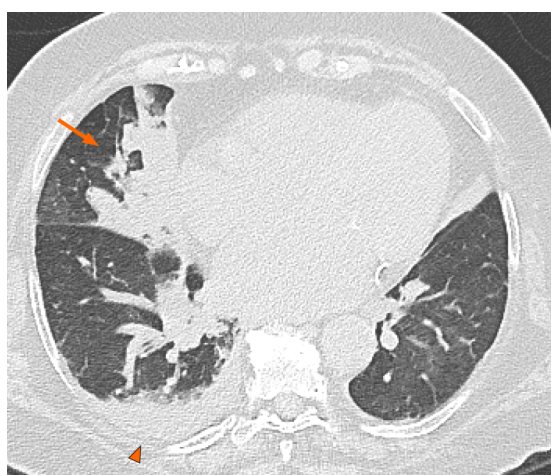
Axial computed tomography image shows right lung consolidation (arrow) and unilateral pleural effusion (arrowhead) in a 64-year-old man with bacterial pneumonia.
